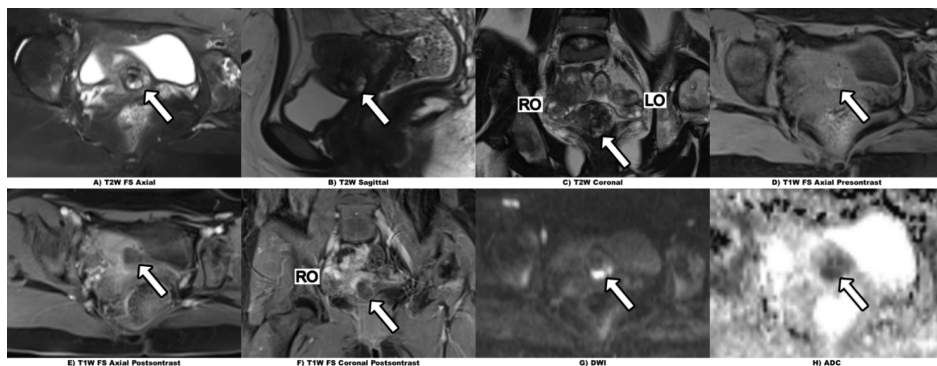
MRI images of hemorrhagic degeneration of intramural leiomyoma.
